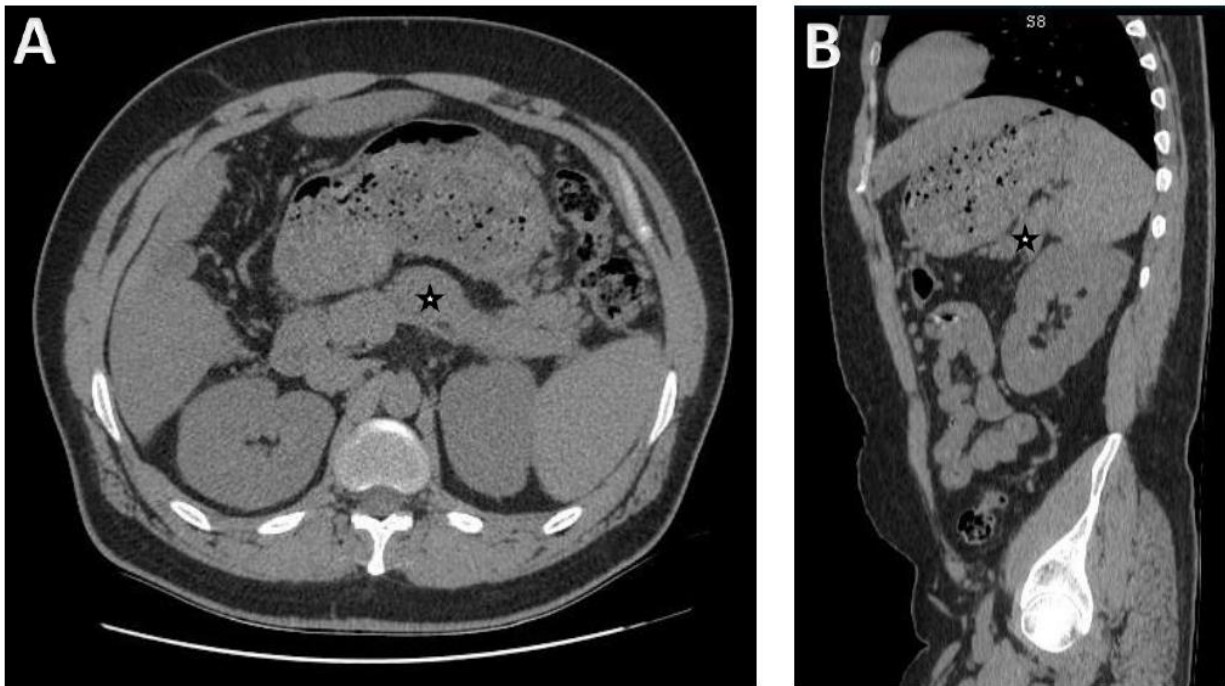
Figure 3. Axial (A) and sagittal (B) planes of CT scan of the patient's abdomen, 3 months after Evolocumab treatment, showing near normal pancreatic structures (star).
